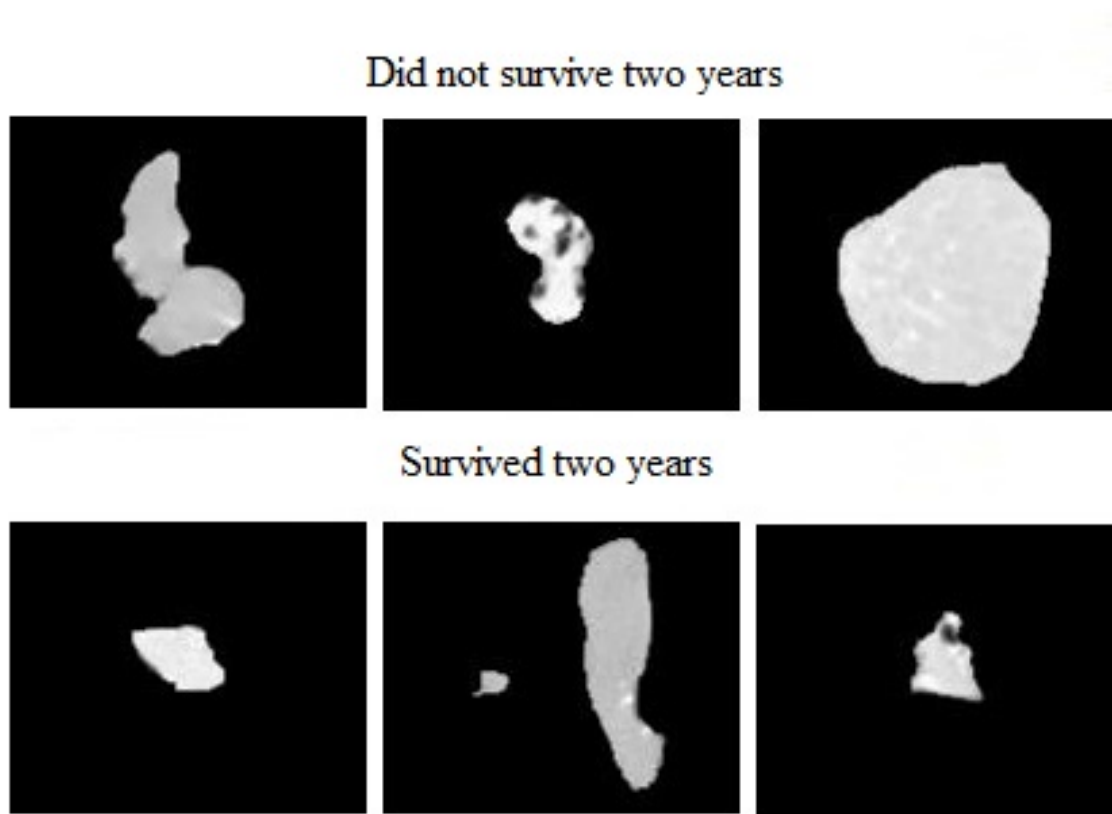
These exemplars show the example input for the patients of a single CT slice for NSCLC image set that were correctly classified by the CNN.
